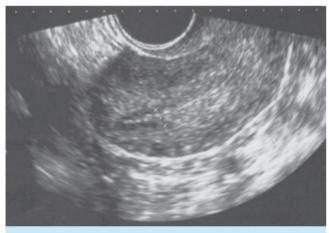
Endovaginal ultrasound of patient. No evidence of retained products of conception. Left anterolateral wall shows calcified lesion measuring 18.5x17.4mm. Endometrial thickness is 5.3 mm.
